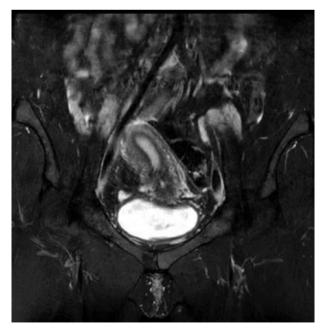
MRI T2W coronal view showing the unicornuate uterus. The uterus is curved (to the right side), elongated, and has a banana-shape. The uterine volume is reduced. No rudimentary horn is noted on its left side.
